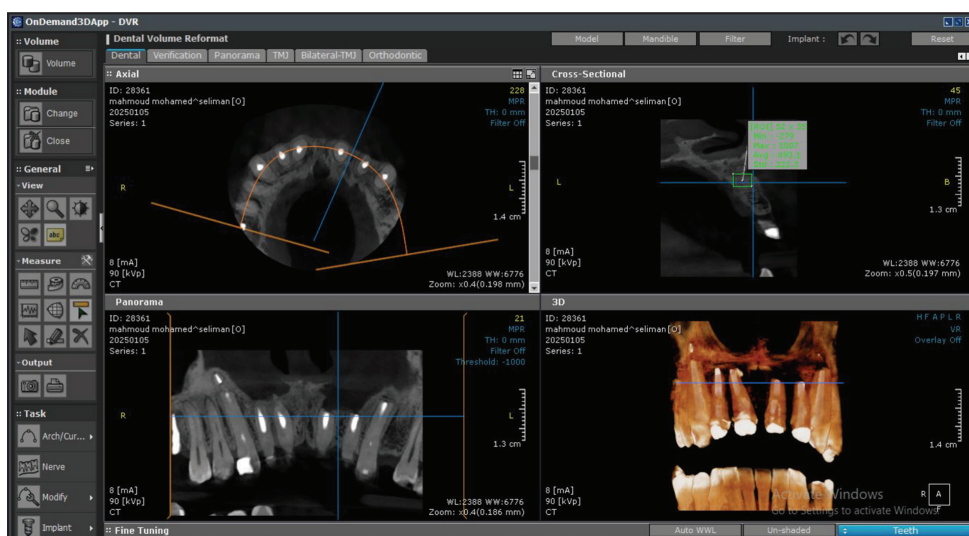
Bone density and healing on CBCT
